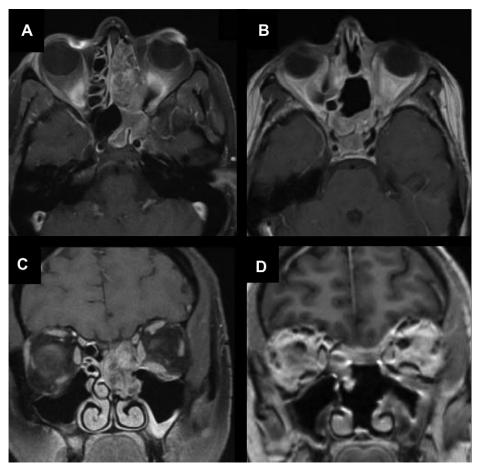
(A) Axial and (C) coronal preoperative postcontrast-enhanced T1-weighted magnetic resonance images of a 40-year-old female patient with a seromucinous adenocarcinoma. Before surgery, the patient was radiated. (B) Axial and (D) coronal postoperative magnetic resonance images after an expanded endoscopic endonasal approach with nasoseptal flap showed complete removal of the tumor. All surgical margins were tumor negative.
